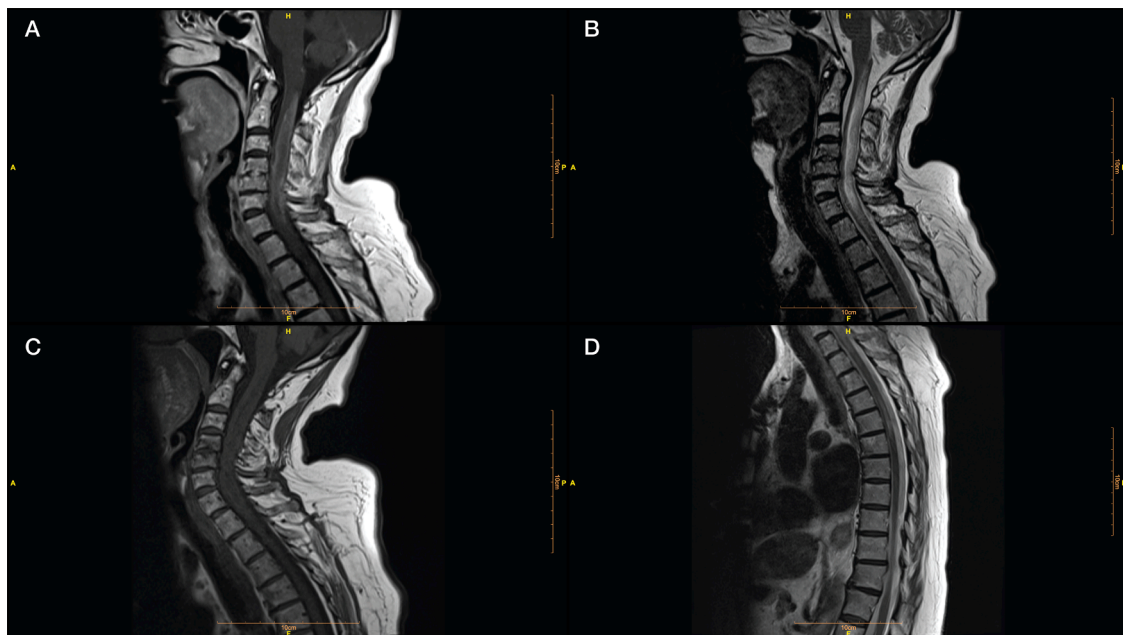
Spinal cord magnetic resonance imaging (MRI) following COVID-19 vaccination. Cervical MRI demonstrated a low T1-weighted long segment hemorrhagic lesion (A) and a high T2-weighted long segment myelitis (B) with peripheral enhancement in post-Gadolinium T1-weighted image (C). Thoracic T2-weighted MR image determined long segment myelitis (D).
